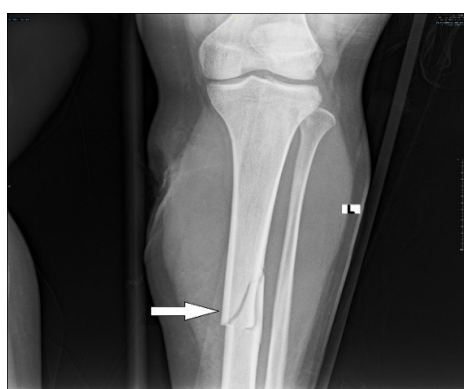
X-ray of two shin bones at the time of admission: Fracture of the left middle third of the tibia
